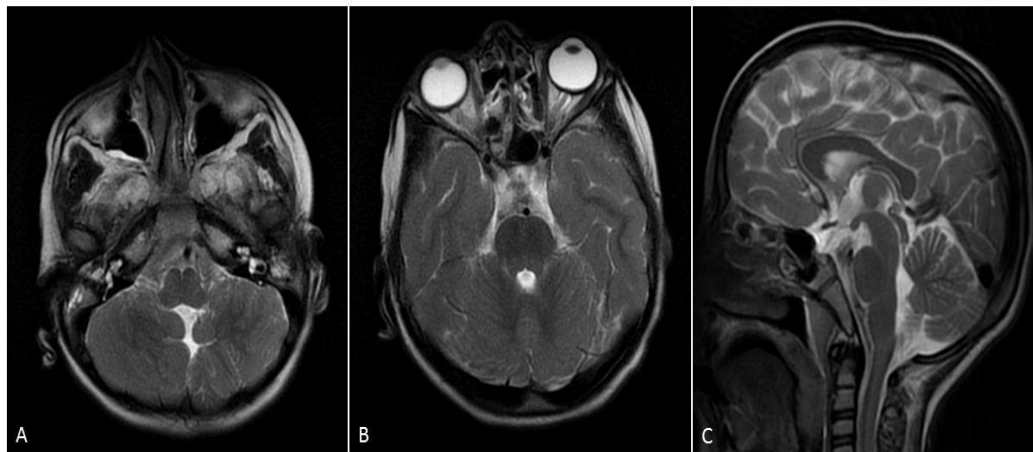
8-year-old male. A) Mild dysmorphism in cerebellar sulcus at the level of cerebellum inferior on the axial T2-weighted image. B) Slight pachygyria in bilateral temporal gyri on the axial T2-weighted image. C) Sagittal T2-weighted image shows brain stem compartments and corpus callosum in a normal configuration, while mild hypoplasia is seen in the inferior cerebellar vermis.
